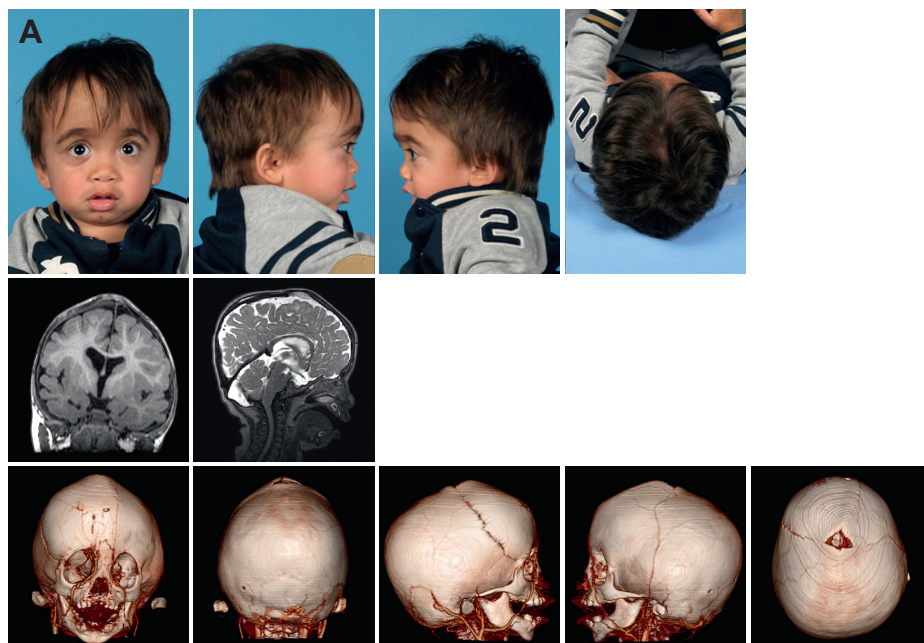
Patient 10, MPS II, 1.5 years old. Photographs show the distinct facial features, MRI T2 flair and 3D CT scan shows the bulging anterior fontanel (volcano sign) with plagiocephaly at the right anterior site of the head. 3D CT scan shows the premature closure of the left coronal suture, the sagittal suture and both lambdoid sutures.
